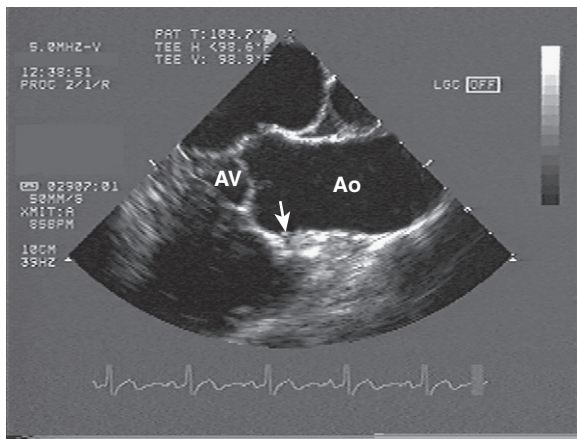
Longitudinal view of the ascending aorta (Ao) by transesophageal echocardiography. The entire ascending aorta is visualized from the aortic valve (AV) to the initial curvature of the aortic arch. The takeoff of the right coronary artery is visible (arrow).
